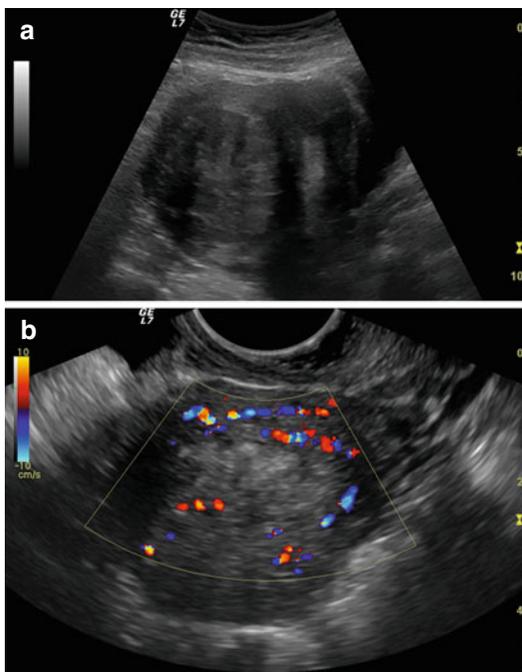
A ultrasonographic scan of uterine adenomyoma without and with Eco Doppler scan
